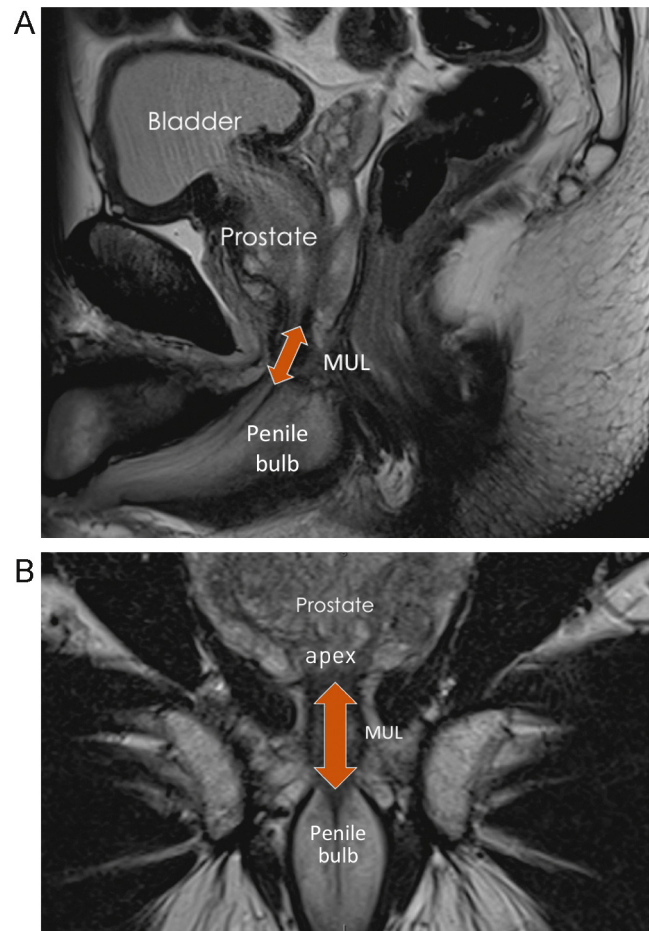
T2-weighted (A) sagittal and (B) coronal magnetic resonance images^a for the measurement of membranous urethral length (MUL).
